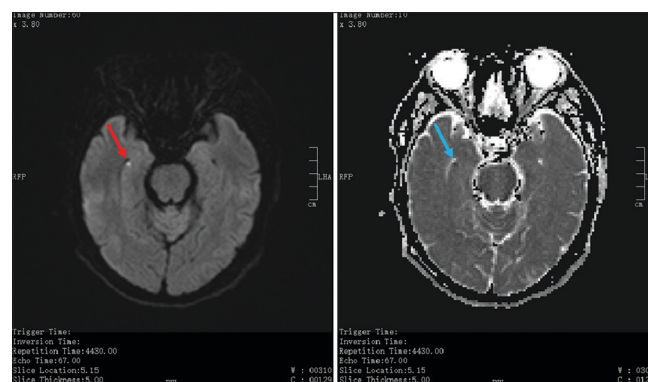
Punctate hippocampal diffusion weighted imaging (DWI) hyperintensity seen in a patient whose scan was done 21.7 h after symptom onset. A single round hippocampal DWI hyperintensity (red arrow) is seen on the right hippocampus measuring 0.4 cm in size, with a corresponding signal dropout on the analog-to-digital converter sequence (blue arrow)
